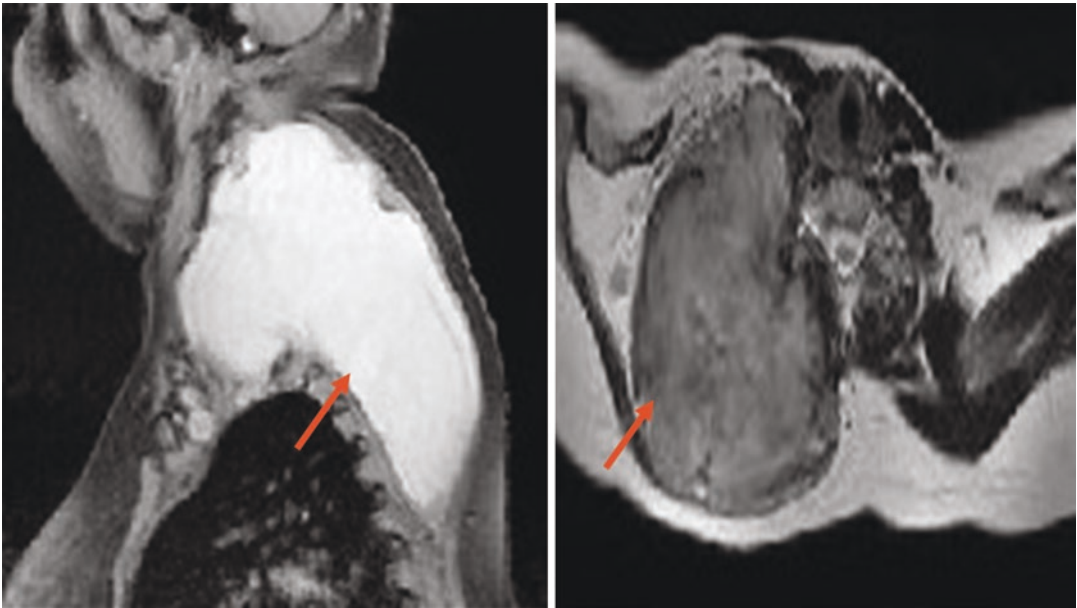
An extensive base-of-neck tumour which is enhanced on MRI, with a well-defined capsule
